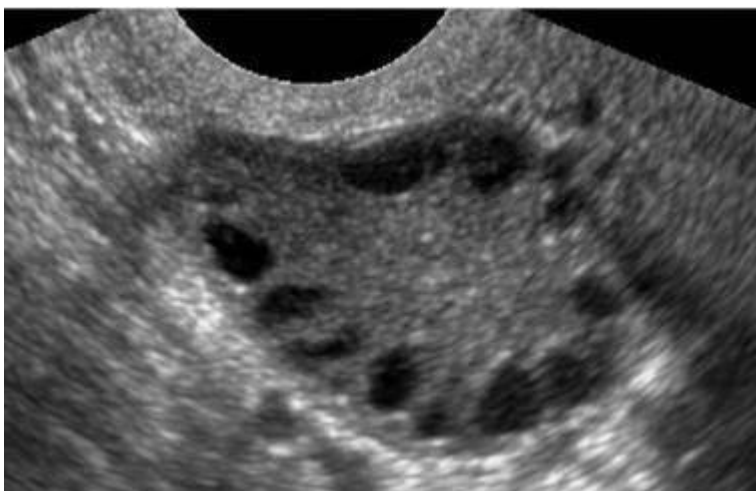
Polycystic ovaries. (Brazilian Journal of Ultrasonography, 2012)
